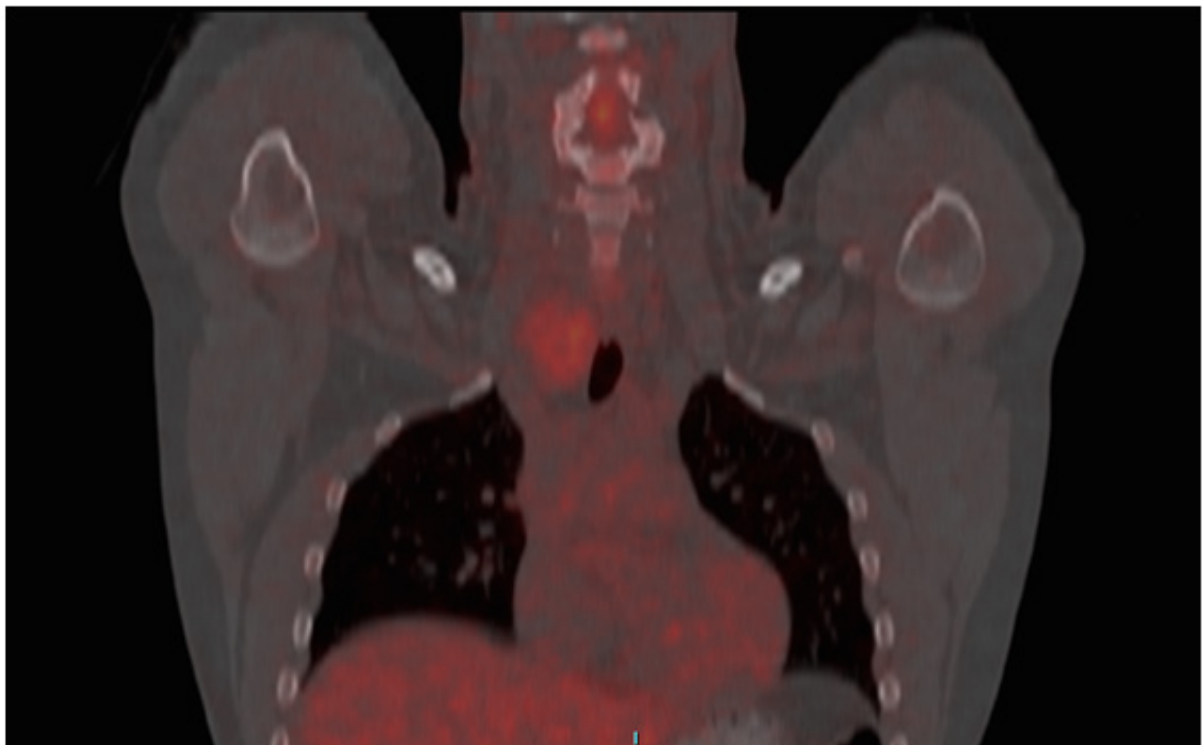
PET-CT scan showing a soft tissue mass in the right neck Level IV compartment.
